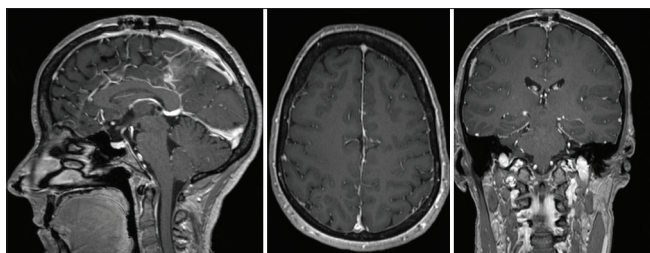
Three-month postoperative magnetic resonance imaging
